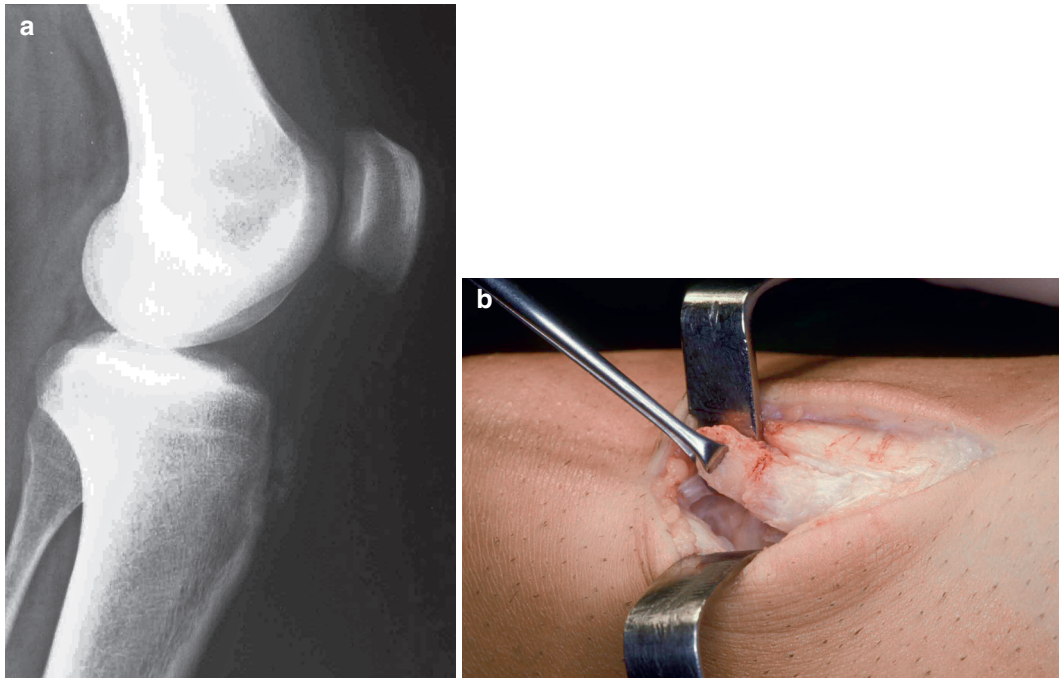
This is a patient who presented with swelling and pain in the anterior tibial tubercle. Lateral x-ray showing ossicles in the anterior tibial tubercle (a). Excision of the ossicles via a transtendinous approach (b)
